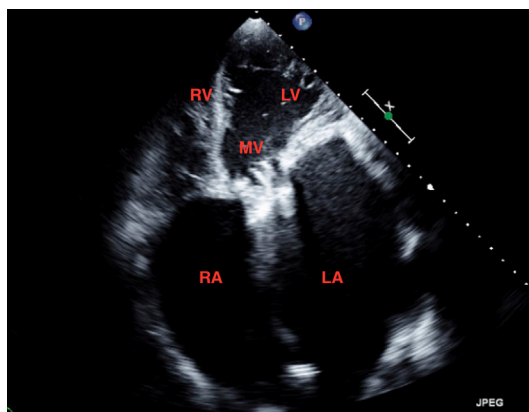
A four-chamber view on a transthoracic echocardiogram demonstrating biatrial enlargement.
